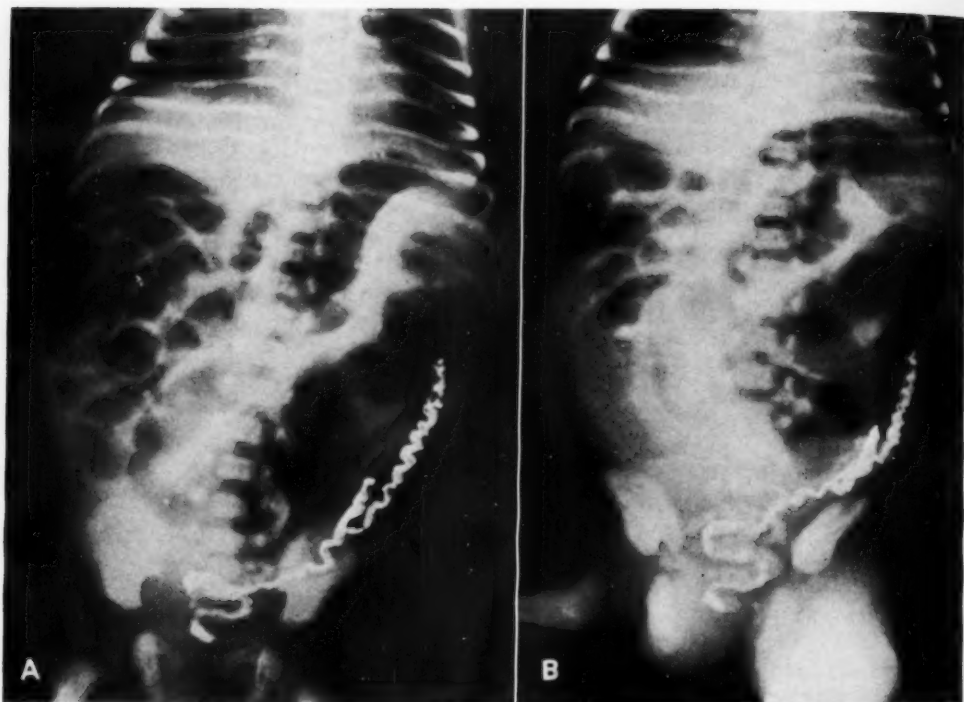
Case VI. Uncomplicated meconium ileus. Supine (A) and upright (B) abdominal roentgenograms at three days of age, showing dilated gas-filled loop of bowel with no fluid level in the upright view.
